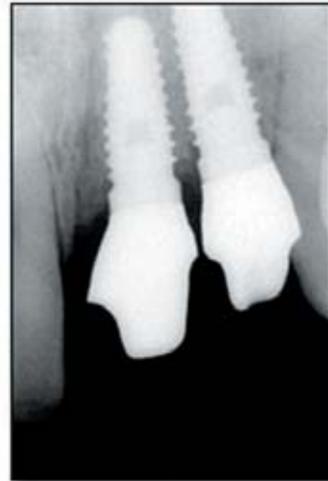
Follow-up radiograph with zirconium abutments in place.
